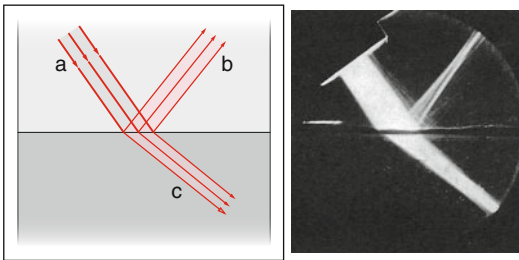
Reflection and refraction of ultrasound at the interface between two media. *Left:* (a) Incoming sound beam. (b) Reflected beam. (c) Refracted beam. The velocity of sound is greater in the lower medium. Therefore, refraction is away from the normal to the surface. *Right:* Historical image from A. Giacomini (1949). *Upper medium:* water. *Lower medium:* petroleum ether. (From Giacomini A (1949) *Il Nuovo Cimento*, 6. With permission)
